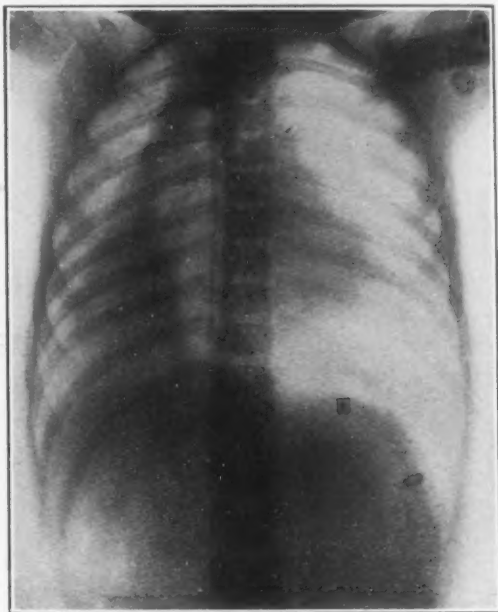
Radiograph by Dr. George C. Johnston, showing foreign body (primer) at the bottom of the pleural cavity of a child of 4 years. Foreign body removed by pleuroscopy.
